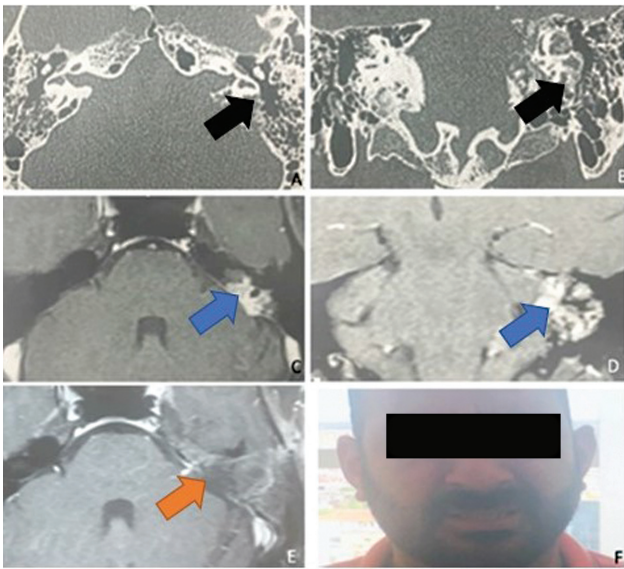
Case 1, axial (A) and coronal (B) CT scan of the temporal bone in the bone window, showing destruction on the petrous portion of the temporal bone. Axial (C) and coronal (D) MRI scans of the T1 with gadolinium showing tumor inside the mastoid portion of the temporal bone, with involvement of the Trautmann triangle's dura mater. MRI of the T1 with gadolinium 3 months after surgery, showing total resection of the lesion (E) with facial nerve preservation (F). Black arrow: expansive lesion with erosion of the temporal bone's petrous portion. Blue arrow: tumor seen in the MRI scan. Orange arrow: late postoperation exam showing complete tumor resection.
